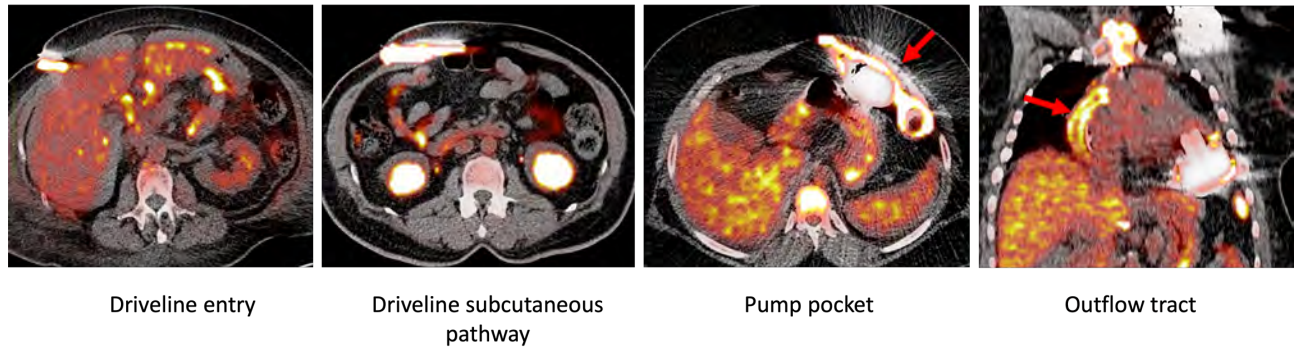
Representative example of fused  $^{18}\text{F}$ -FDG PET/CT showing the different sites of infection as evidenced by increased  $^{18}\text{F}$ -FDG uptake.
